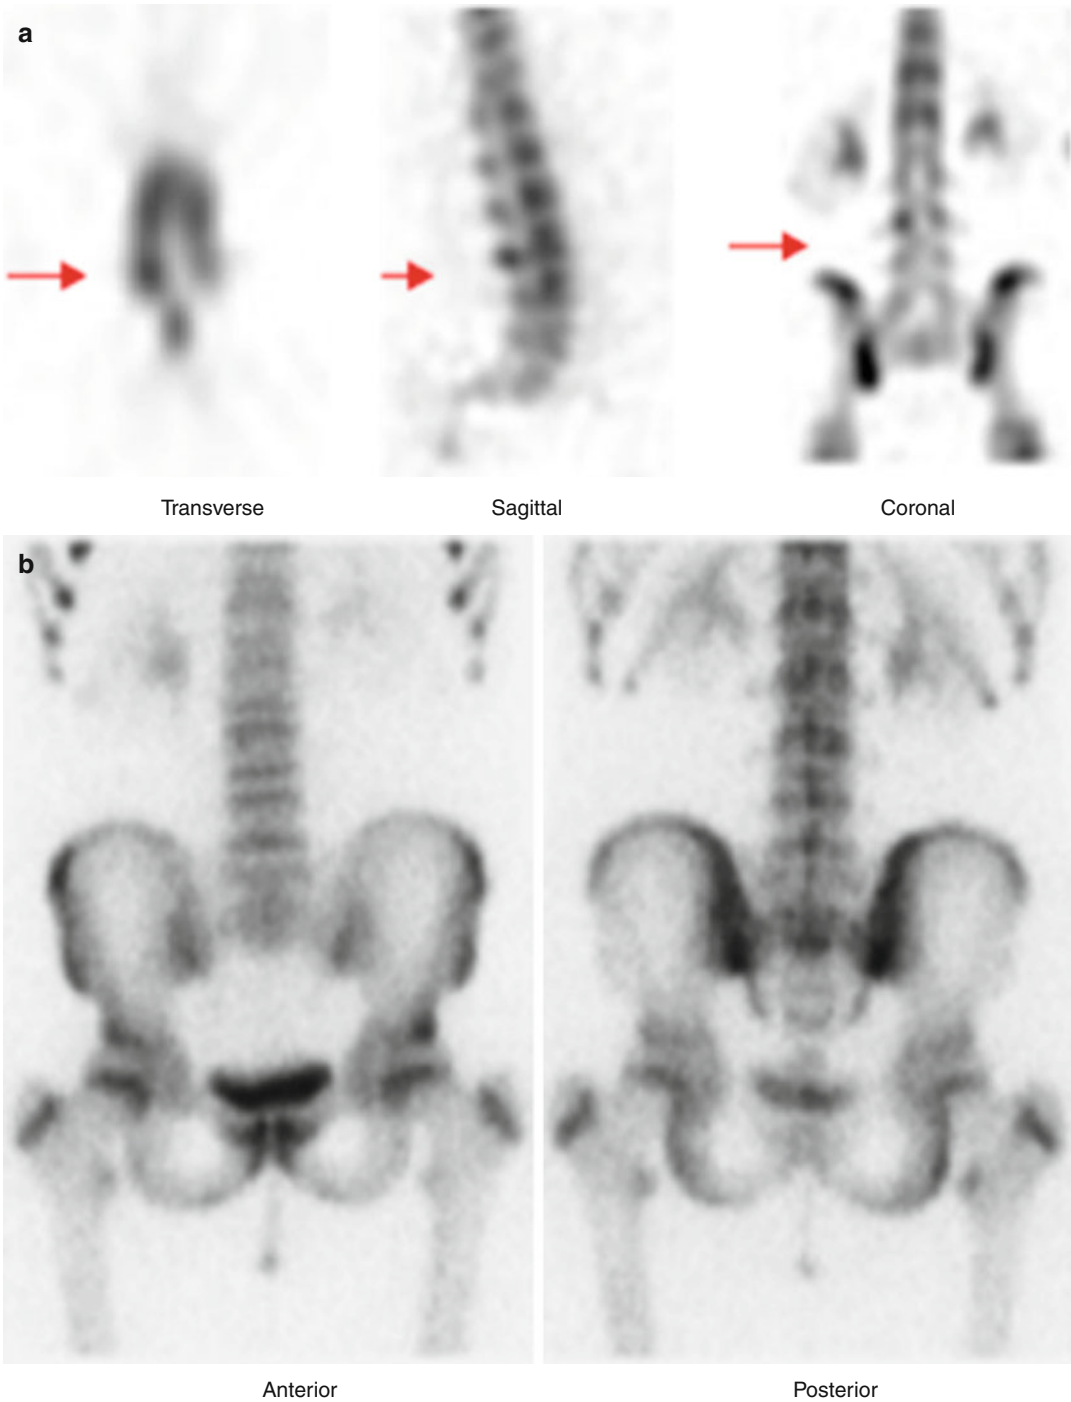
A 15-year-old female figure skater with back pain; added value of SPECT in the detection of pars interarticularis stress: (a) SPECT demonstrates right pars
